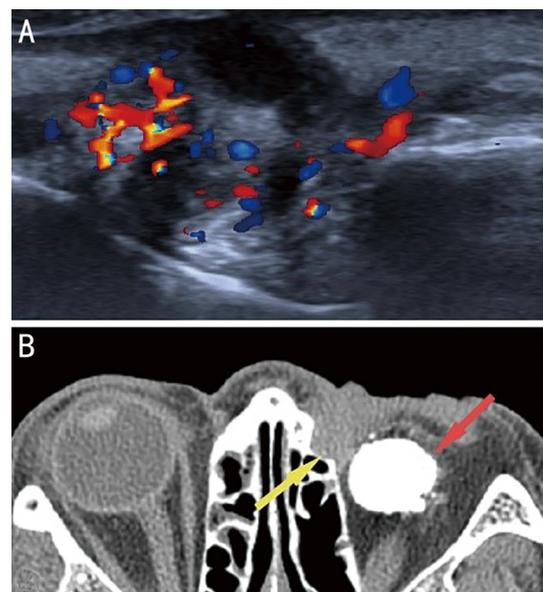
Imaging features of inflammatory granuloma in CDU and CT A: An irregularly shaped mass was observed with a clear, not-smooth edge and uneven internal echoes, with the base adhering to the sac wall was observed. CDU showed abundant blood flow signals. B: CT revealed a soft tissue mass in the lacrimal sac without obvious bone destruction (yellow arrow), and the high-density zone was identified as a hydroxyapatite orbital implant (red arrow). CDU: Color Doppler ultrasound; CT: Computed tomography.
